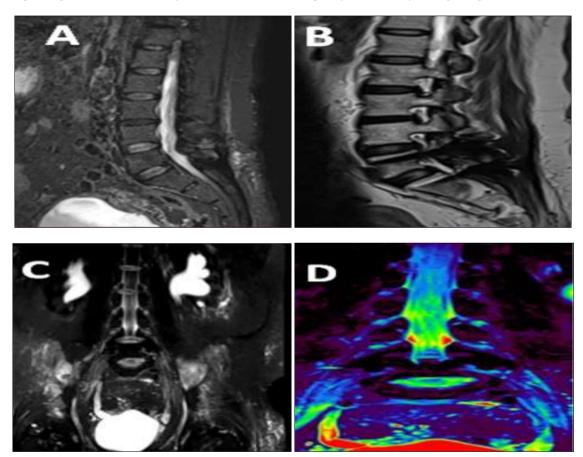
Conventional MRI: sagittal STIR (A) and sagittal T₂ (B):degenerated disc at the level of L3-L4. Old fixation screws for previous spondylolithesis at level of L5 and S1. MRN: 3D STIR (C): no root abnormalities could be seen
